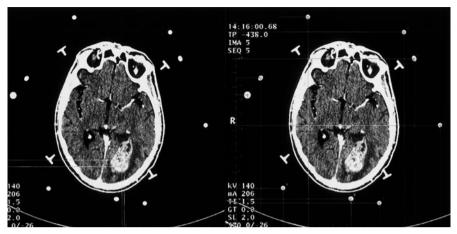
Axial CT brain scans with the CT localiser unit in place. On the right side the 9 carbon fibre rods, including the single large one, are visualised and digitised. On the left side two planned biopsy target sites in the occipital lesion have been digitised
